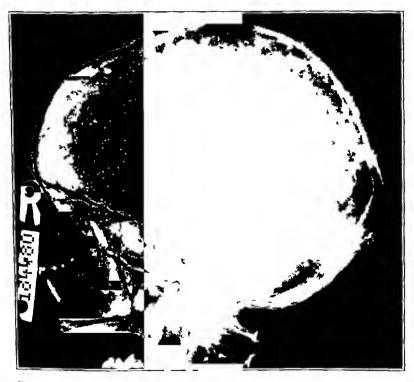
Roentgenogram showing the typical lesions of multiple inveloma in the skull. There are multiple punched-out areas of destruction with no evidence of osseous reaction about them
